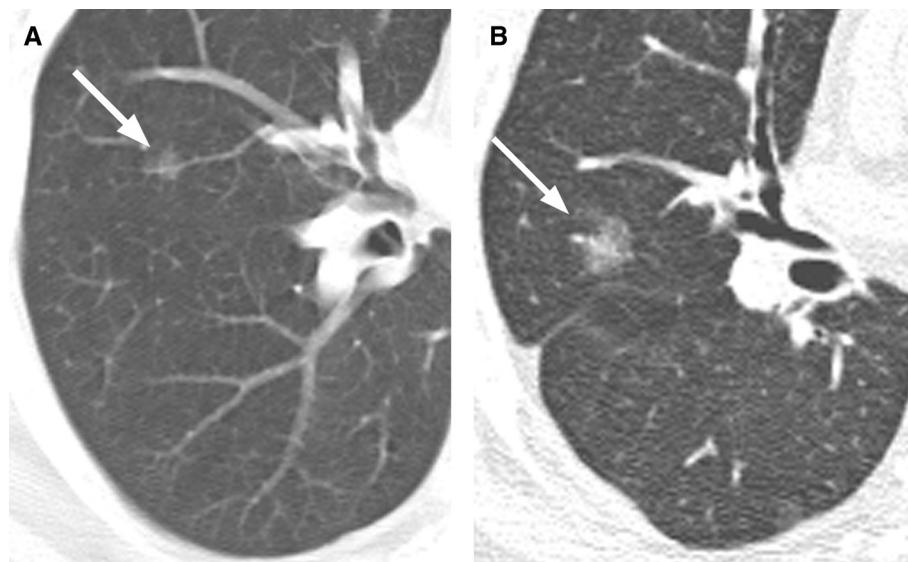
Enlarging ground-glass opacity. (A) Baseline computed tomography (CT), demonstrating an 8-mm ground-glass opacity (arrow) categorized as Lung Reporting and Data System (LU-RADS) 3S (indeterminate; requires serial CT). (B) CT obtained 5 years later, showing enlargement (arrow) to 14 mm (LU-RADS 4B, likely low-grade adenocarcinoma). Segmentectomy demonstrated adenocarcinoma in situ.
